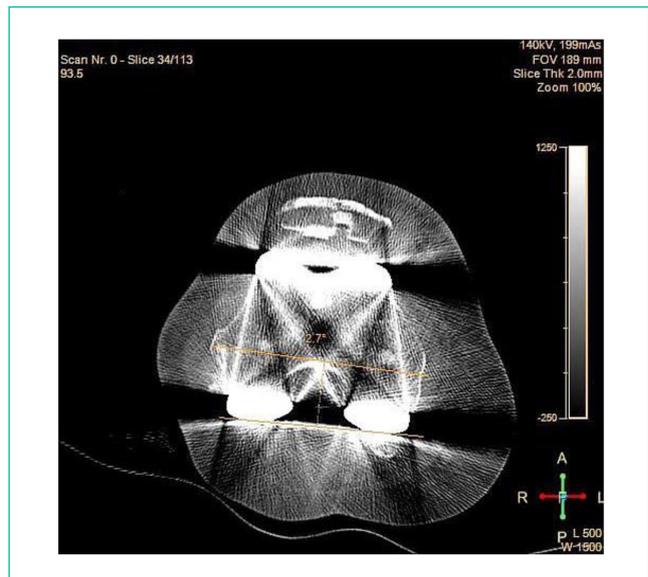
Measurement of external rotation of femoral component using surgical trans-epicondylar Axis (sTEA) and Femoral Prosthesis Posterior Condylar Line (FPPCL) after post-operative using CT Protocol.
